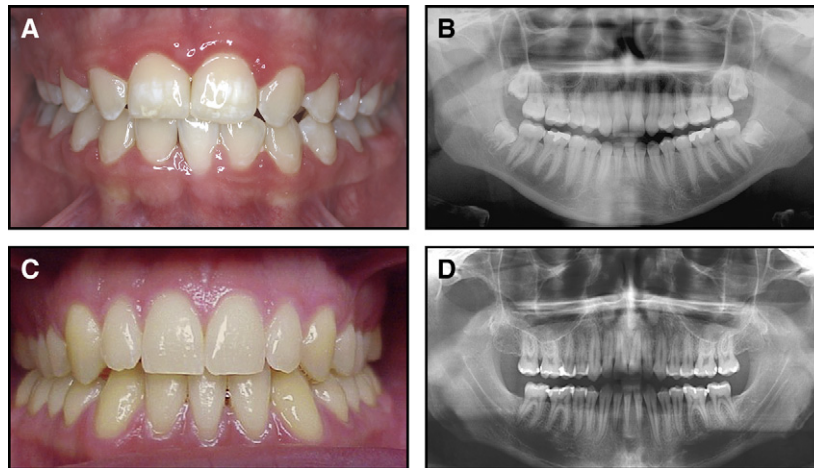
A and B, Patient with a barely noticeable open gingival embrasure; the panoramic radiograph shows root divergence between the mandibular right lateral and left central incisors, as well as an interproximal contact location at the incisal third. C and D, Patient with moderately noticeable open gingival embrasure; the panoramic radiograph shows adequate root parallelism between the mandibular right central and left lateral incisors, and a contact location in the incisal third.
